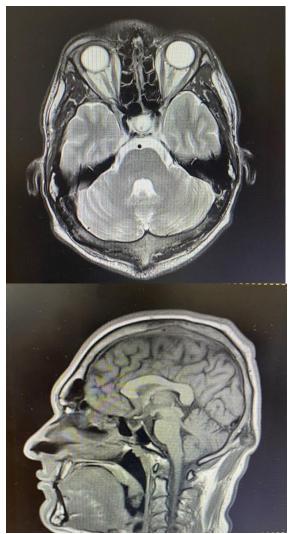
Three months later MRI scan described hypophyseal tumor ablation, without residual tumoral tissue, postoperative empty sella
